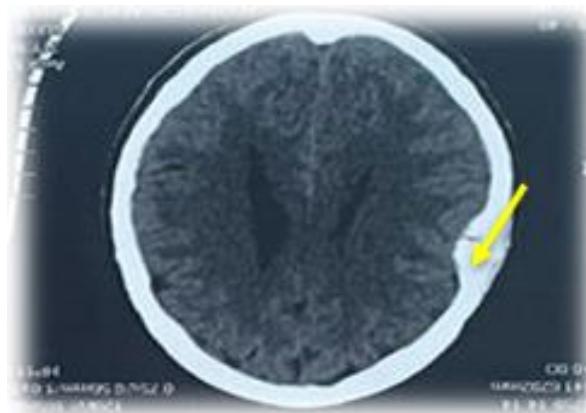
Cerebral CT Scan Revealed Osteolysis of the Cranial Vault, Right Parietal with Intracranial Extension in Contact with the Parenchyma Without Mass Effect.
